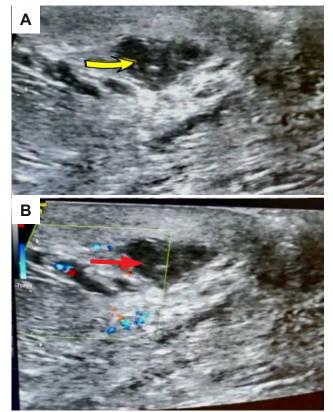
Ultrasound of Breast of 37 Years Female with Swelling in breast. (A) Microfilariae in Subcutaneous Breast Tissue(red arrow). (B) Colour Doppler Imaging Showing Twirling Motion (yellow arrow).
